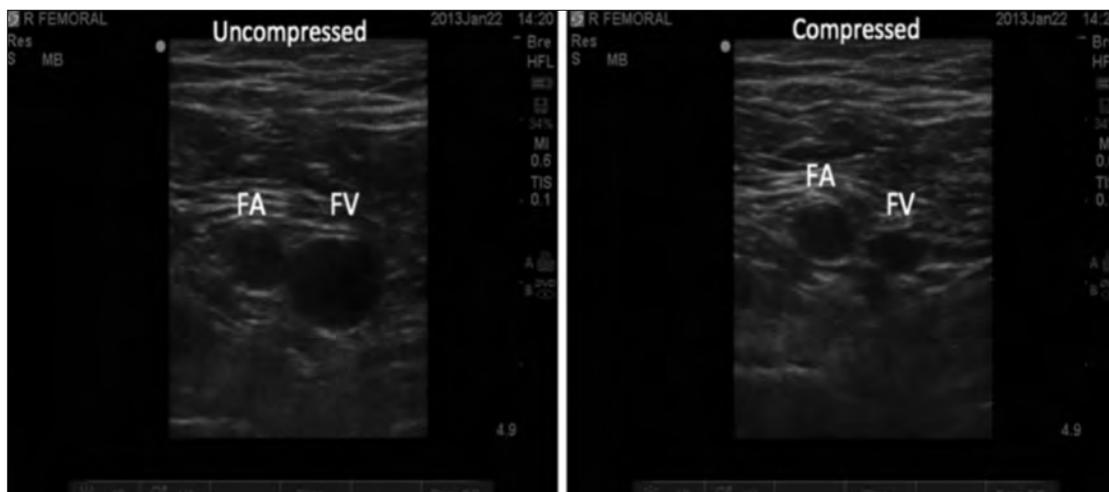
Ultrasound images of the femoral vein (FV) and femoral artery (FA). The image on the left shows the femoral vein uncompressed, and the image on the right shows the femoral vein being compressed by the ultrasound probe. Images courtesy of A. Smith and B. Metcalfe at Memorial University.
